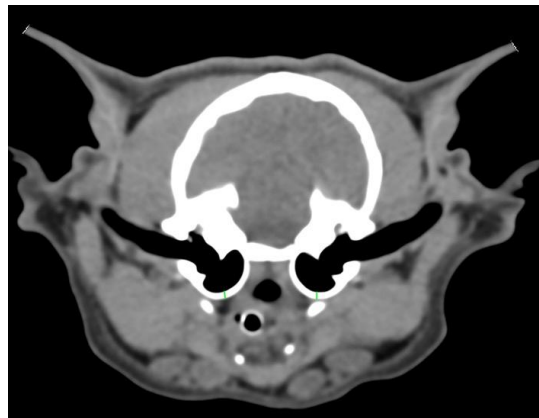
A CT image depicts tympanic bulla thickness measurement (green line) in the transverse plane.
